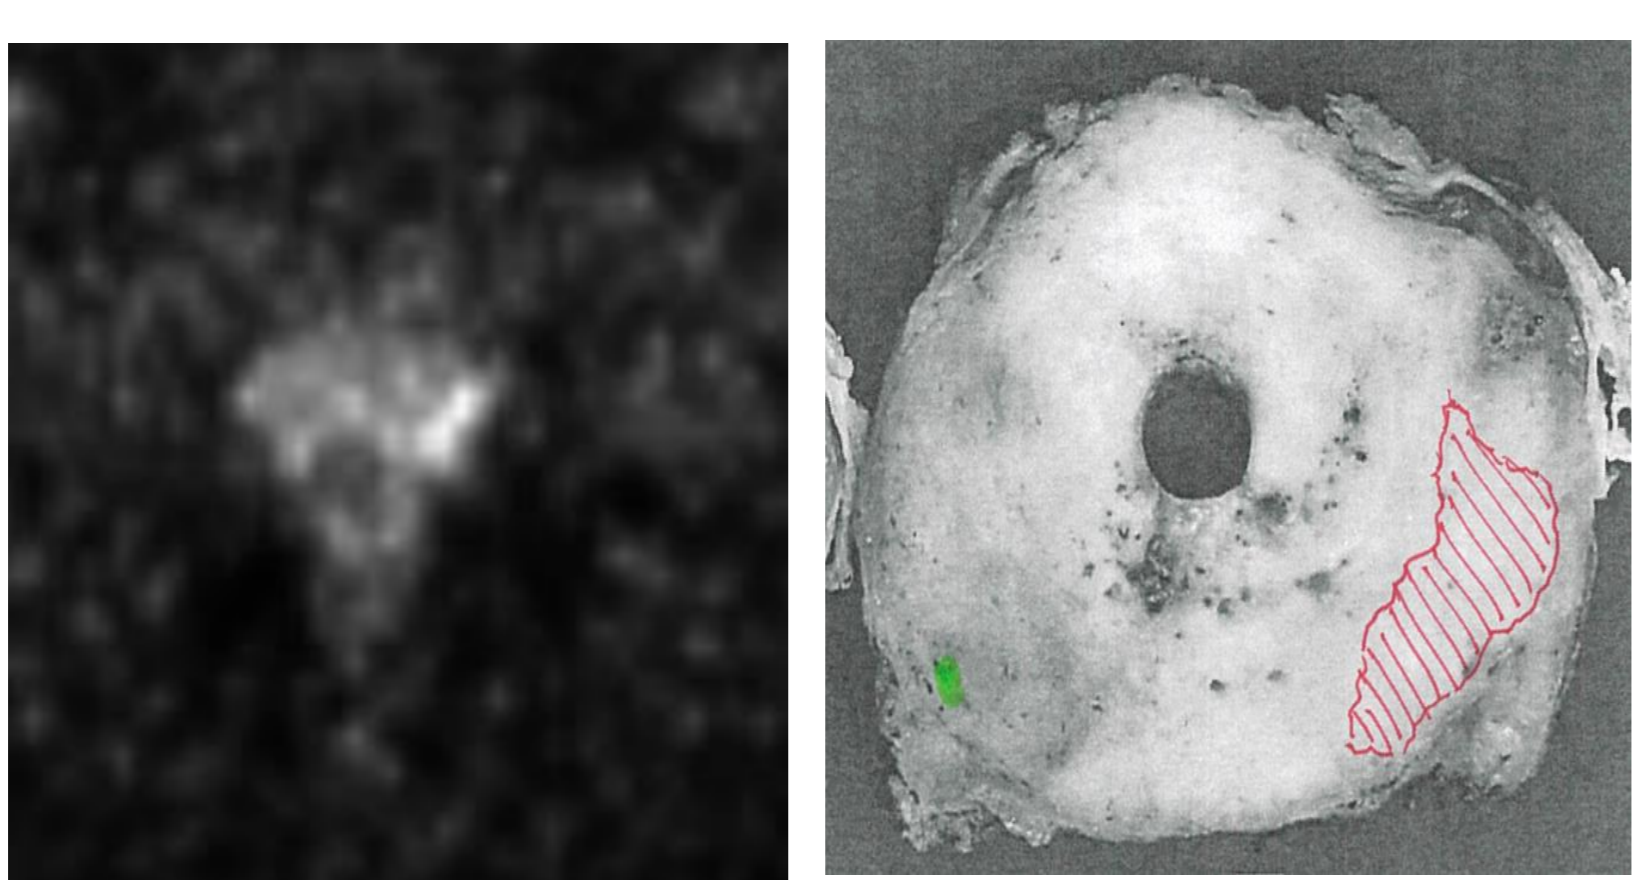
example of a case where PSMA PET/CT (left panel) identified the Index lesions (red lesions, SUV 6.9, Gleason 4+4=8) but did not detect the secondary lesion (green lesion, Gleason 3+3=6)
